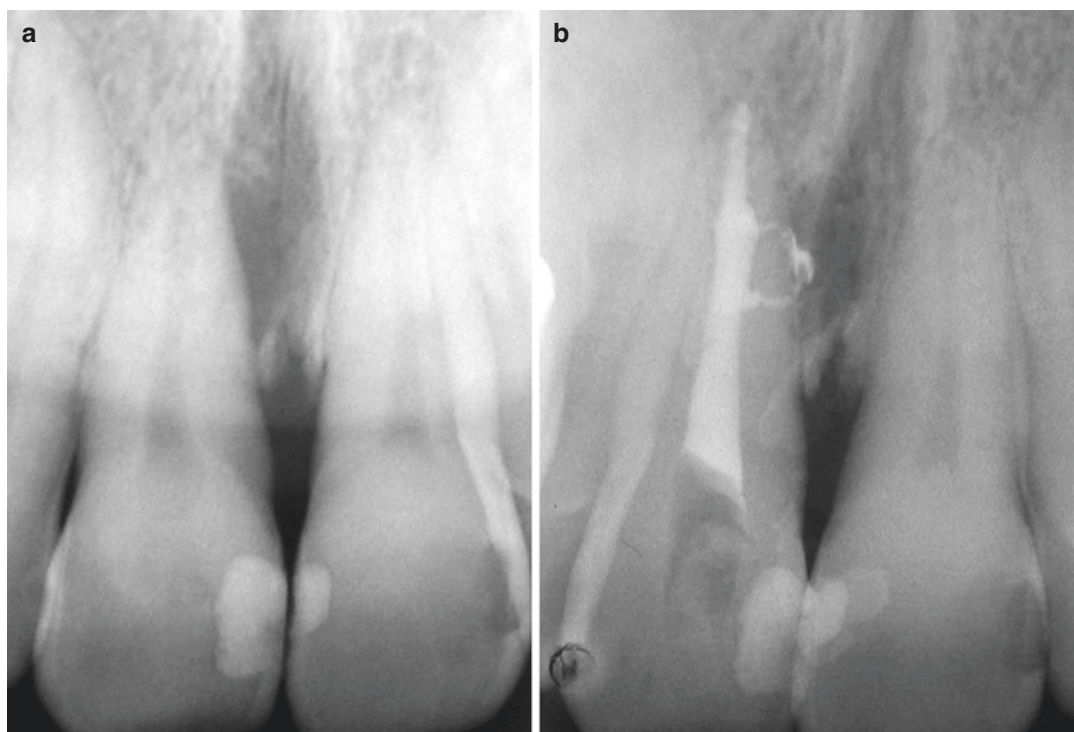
Central maxillary incisor with pulp necrosis and periapical lesion (a). Following root canal filling: lateral canals communicating between the main root canal and periapical lesion are clearly seen (b)
